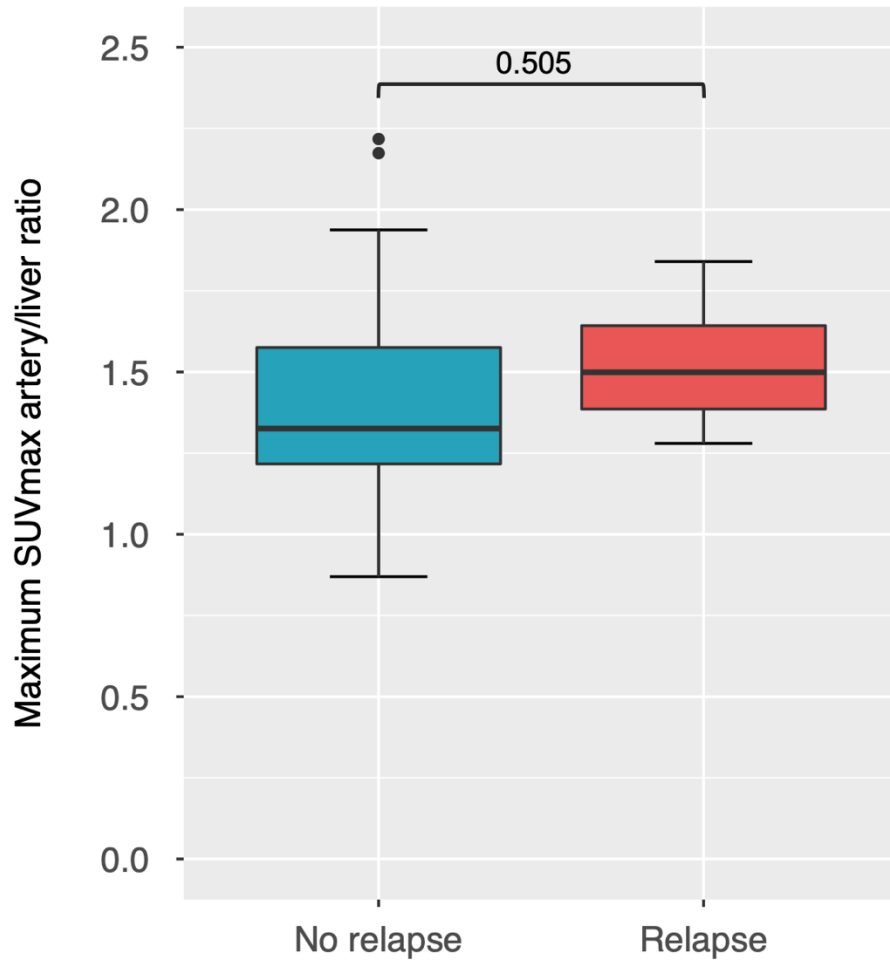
Comparison of the highest SUV_{max} artery/liver ratio between patients who remained in remission (N=12) and patients who relapsed (N=4) after treatment discontinuation.
